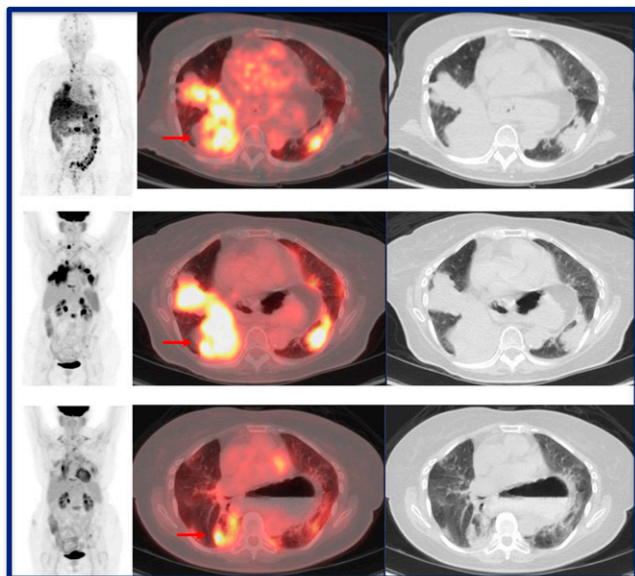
^{89}Zr -trastuzumab PET/CT for prediction of response to trastuzumab emtamine (T-DM1) therapy in patients with HER2 positive lung cancer. PET images acquired with: (top row) pretreatment ^{89}Zr -trastuzumab, demonstrating tracer-avid lung malignancy (arrow); (middle row) pretreatment ^{18}F -FDG PET demonstrating an ^{18}F -FDG-avid right lung malignancy (arrow); and (bottom row) ^{18}F -FDG PET acquired 8 weeks after initiation of HER2-targeted therapy demonstrating a partial metabolic response (arrow). Uptake of ^{89}Zr -trastuzumab was highly predictive of response to T-DM1 therapy.
